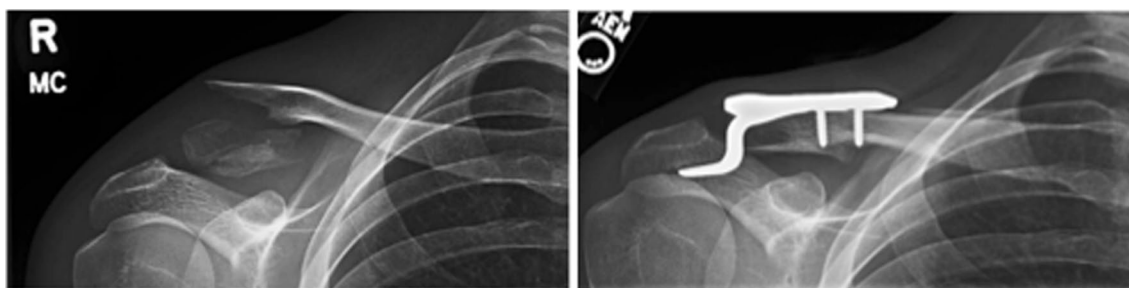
Radiographs demonstrating an unstable distal clavicle fracture and successful union after treatment with a hook plate
